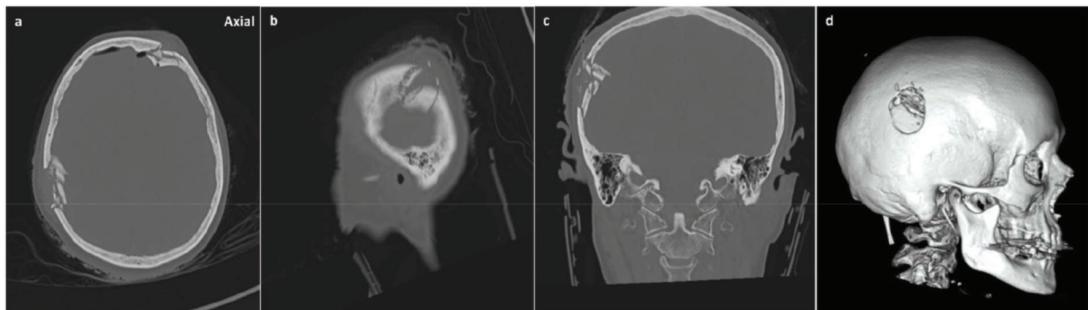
(a)(b)(c) - CT scan of a Male, 80 with comminuted, right parietal depressed skull fracture, with internal displacement of the fracture fragments (d) 3D 3D model of the CT image
